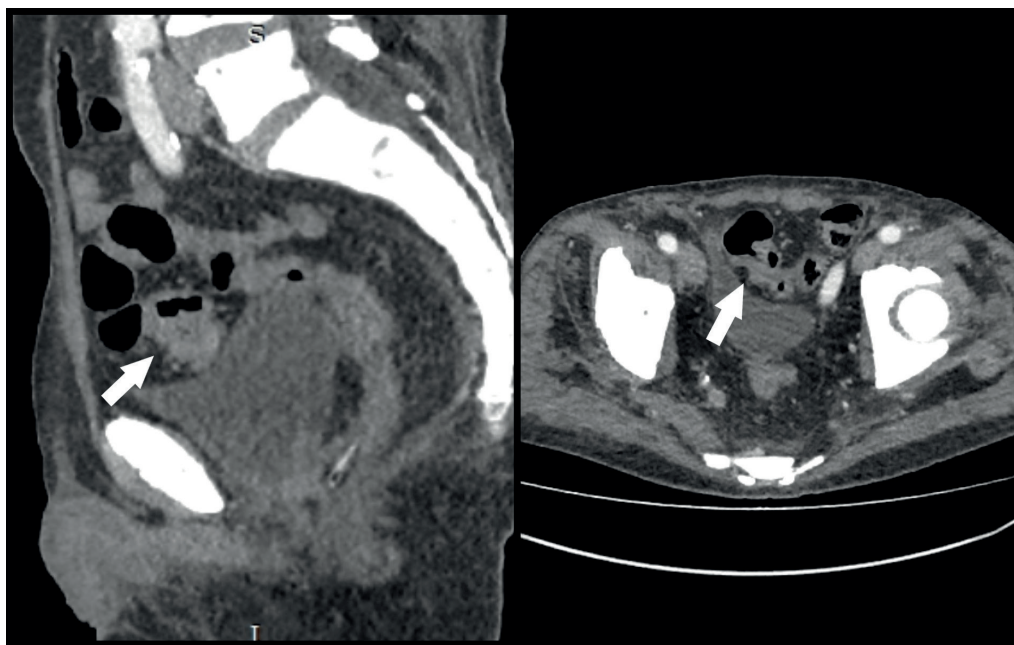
CT image of a tumor in the distal third of the sigmoid colon (white arrows)
